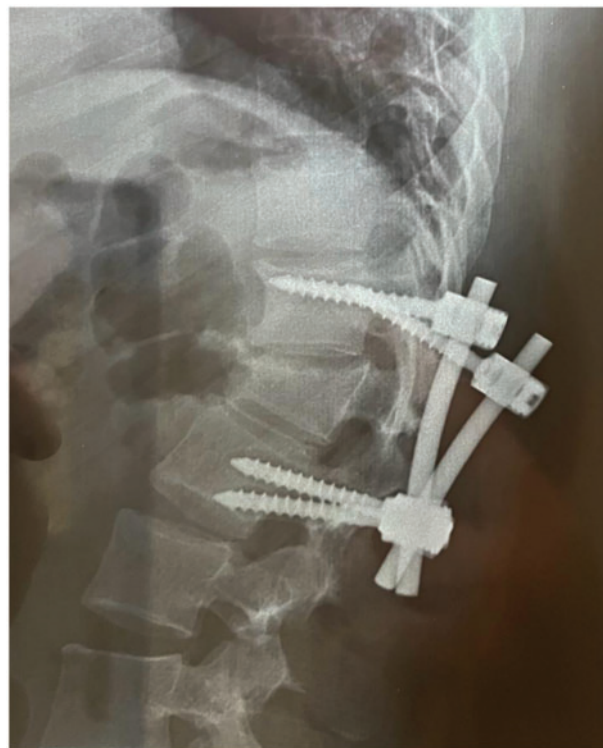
Standard radiograph of the dorsolumbar spine in profile, showing dislocation of the osteosynthesis material.
